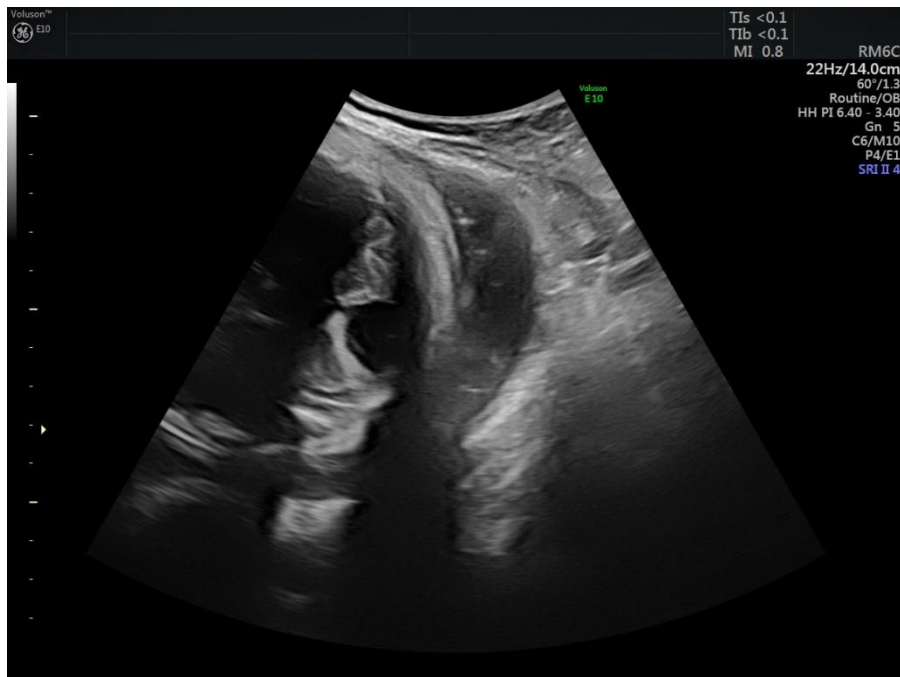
2D Ultrasound fetal scan showing a Dandy-Walker variant.
